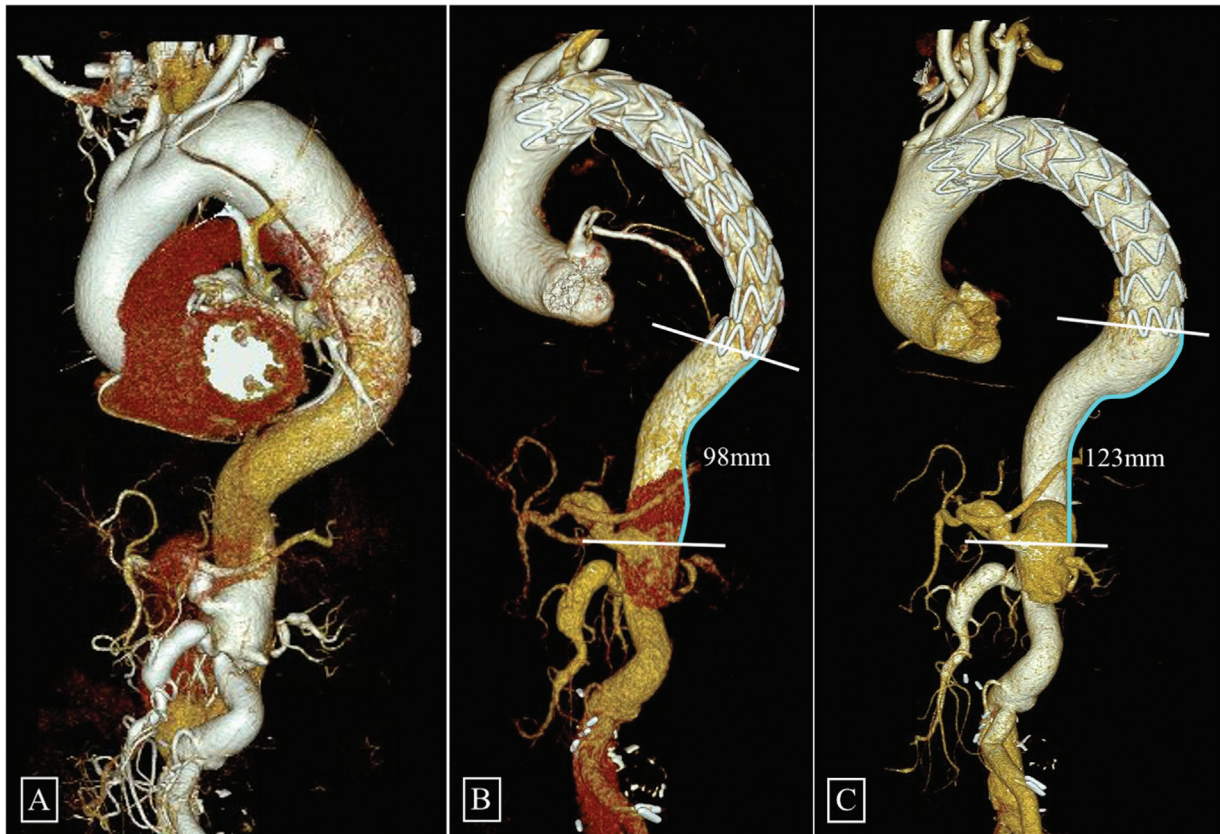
Volume rendered computed tomography (CT) images of a patient with type B aortic dissection (TBAD) at baseline (A). The patient underwent a thoracic endovascular aortic repair (TEVAR) in proximal landing zone 2 due to inadequate landing zone distal to the left subclavian artery (LSCA) (B). The follow-up CT done 16 months postprocedure (C) showed significant migration at the distal end of the stent graft (25 mm). The patient also had a significant aortic elongation at the last follow-up (~40 mm) compared with the baseline scan.
